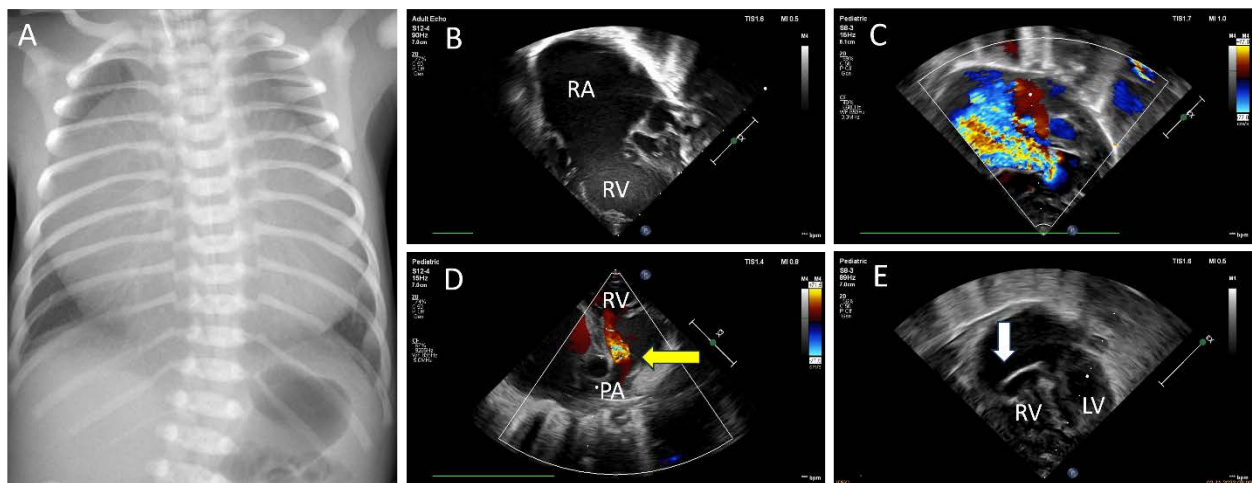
Severe tricuspid valve regurgitation in a 1 day-old-newborn operated on with tricuspid valve reconstruction using CorMatrix tube. A. Chest X ray in anteroposterior view. Cardiomegaly with pulmonary compression. B. Transthoracic echocardiography (TTE). 2DE in apical 4-chamber view showing severely dilated right atrium and right ventricle with left heart compression. C. TTE. 4-chamber view with color Doppler flow showing severe tricuspid valve regurgitation with right heart volume overload. D. TTE. Short parasternal view with color Doppler flow showing pulmonary regurgitation. E. TTE. Apical 4-chamber view in 2DE showing reconstructed tricuspid valve in systole (white arrow)
